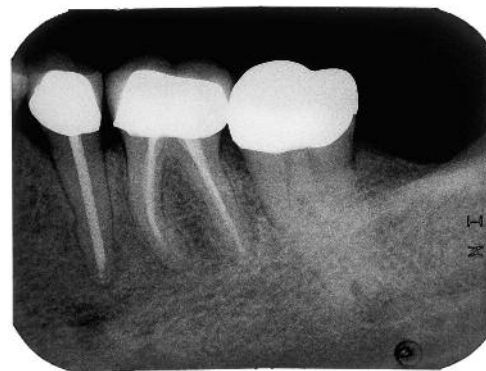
Control radiograph 18 month later.
